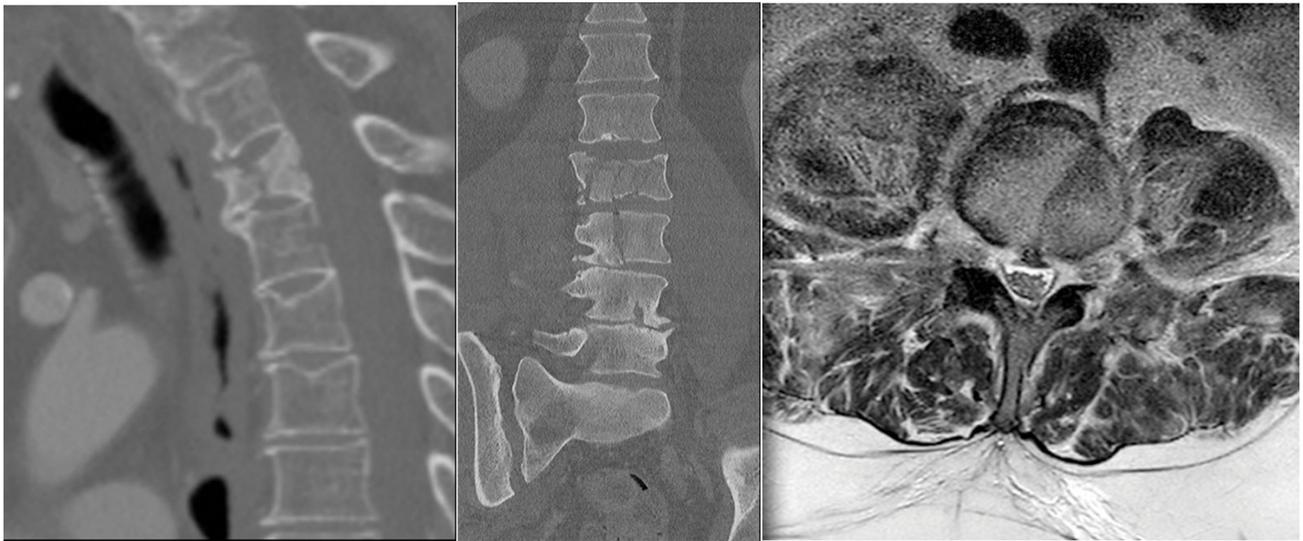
Split or pincer type fracture (AO Classification: A2, not featured in TLICS). Sagittal (2a) CT slice demonstrates a coronal split fracture in the upper thoracic spine. Note that the fracture involves both superior and inferior end plates, but does not involve the posterior vertebral cortex. This should be differentiated from a sagittal split fracture (shown in Coronal CT (2b) and Axial MR (2c) which breaches the superior and inferior end plates as well as the posterior vertebral cortex and therefore involves two columns and is potentially unstable. Note the additional crush fracture at the level above in 2b.
